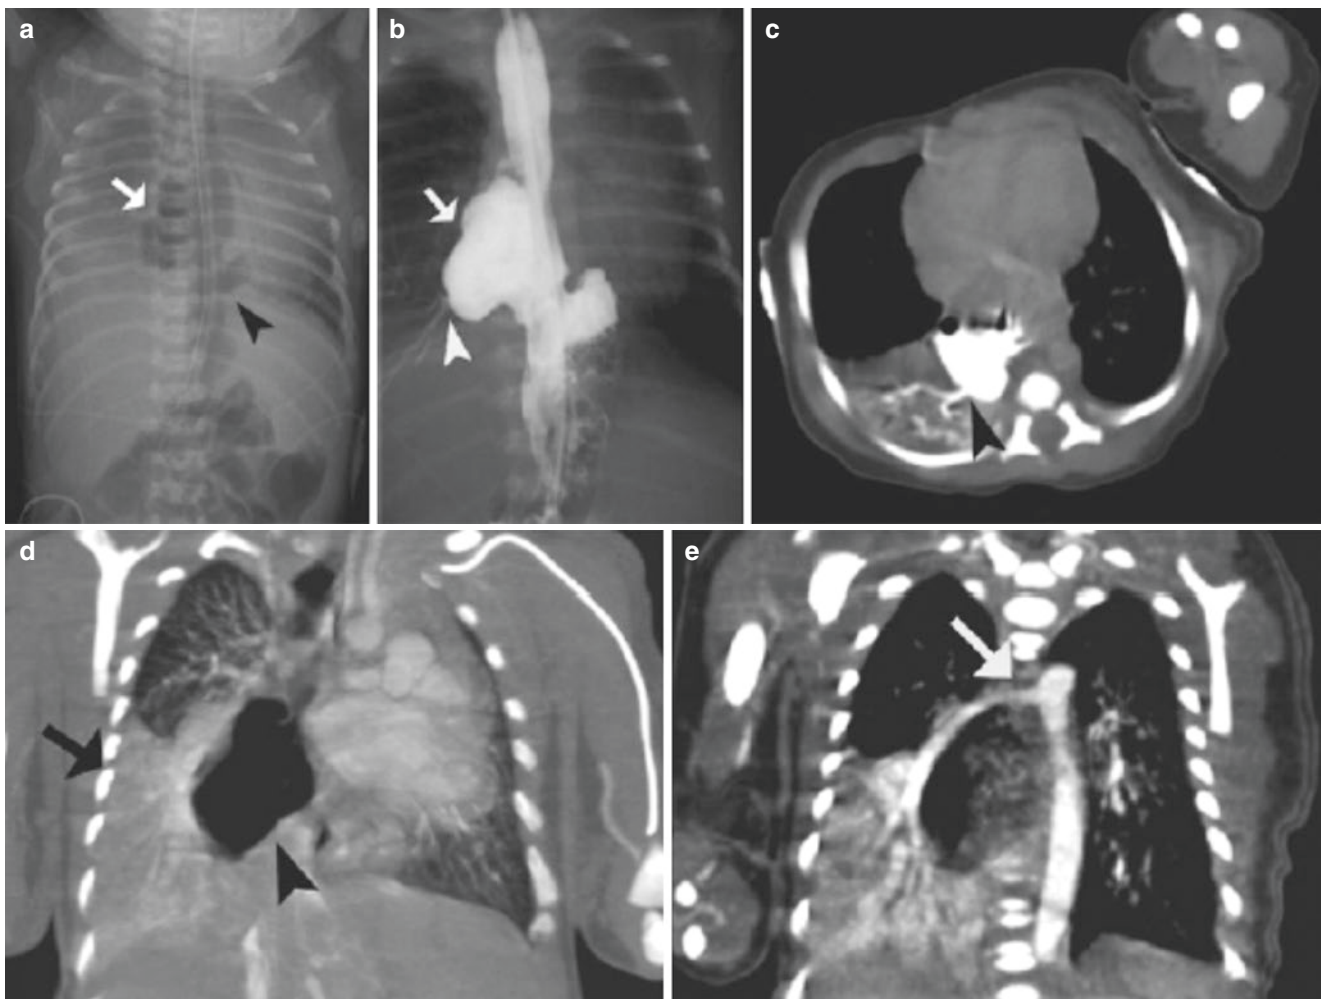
A 3-day-old boy with bronchopulmonary foregut malformation with systemic arterial supply and bronchial connection to gastrointestinal tract. (a) Frontal radiograph of the chest and abdomen shows dense opacification of right lower lobe silhouetting the right hemidiaphragm. There is also right lateral pleural effusion. An air-filled cystic structure (arrow) is seen in the medial right hemithorax. Additionally, there appears to be a hiatus hernia (arrowhead). (b) Esophagram shows the right medial lucent cystic lesion (arrow) fills directly from the esophagus and the subdiaphragmatic stomach is small. Also seen is filling of a distal branching structure (arrowhead) extending to the right
